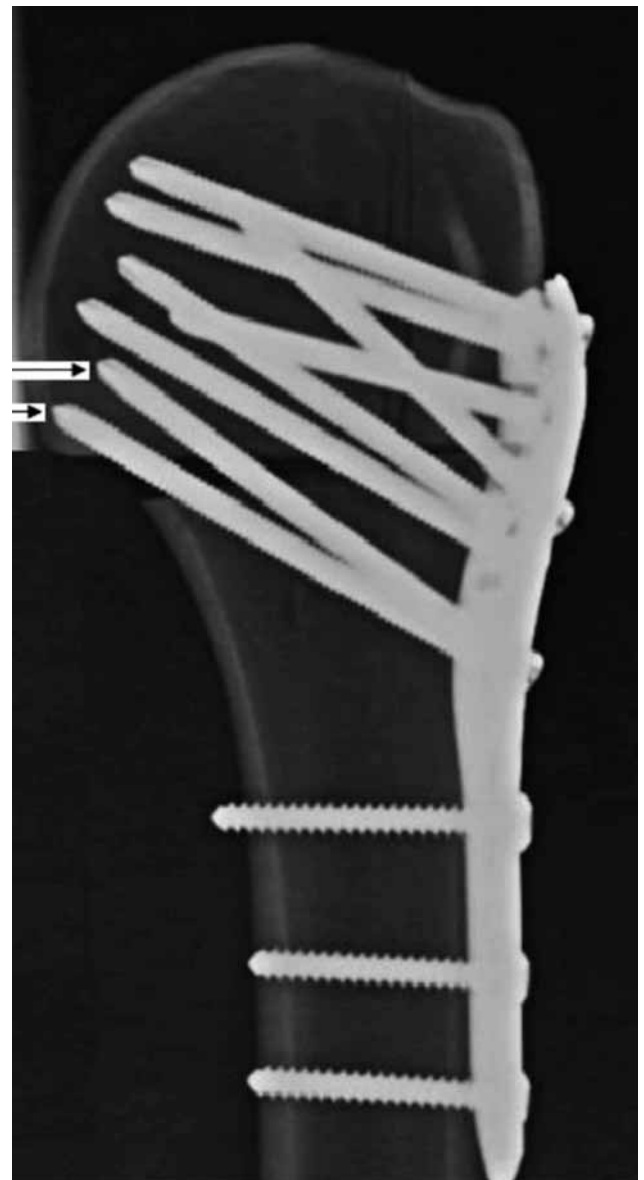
Radiograph showing a 3-part proximal humeral fracture fixed with a locking plate and screws, including the inferomedial screws (arrows)
